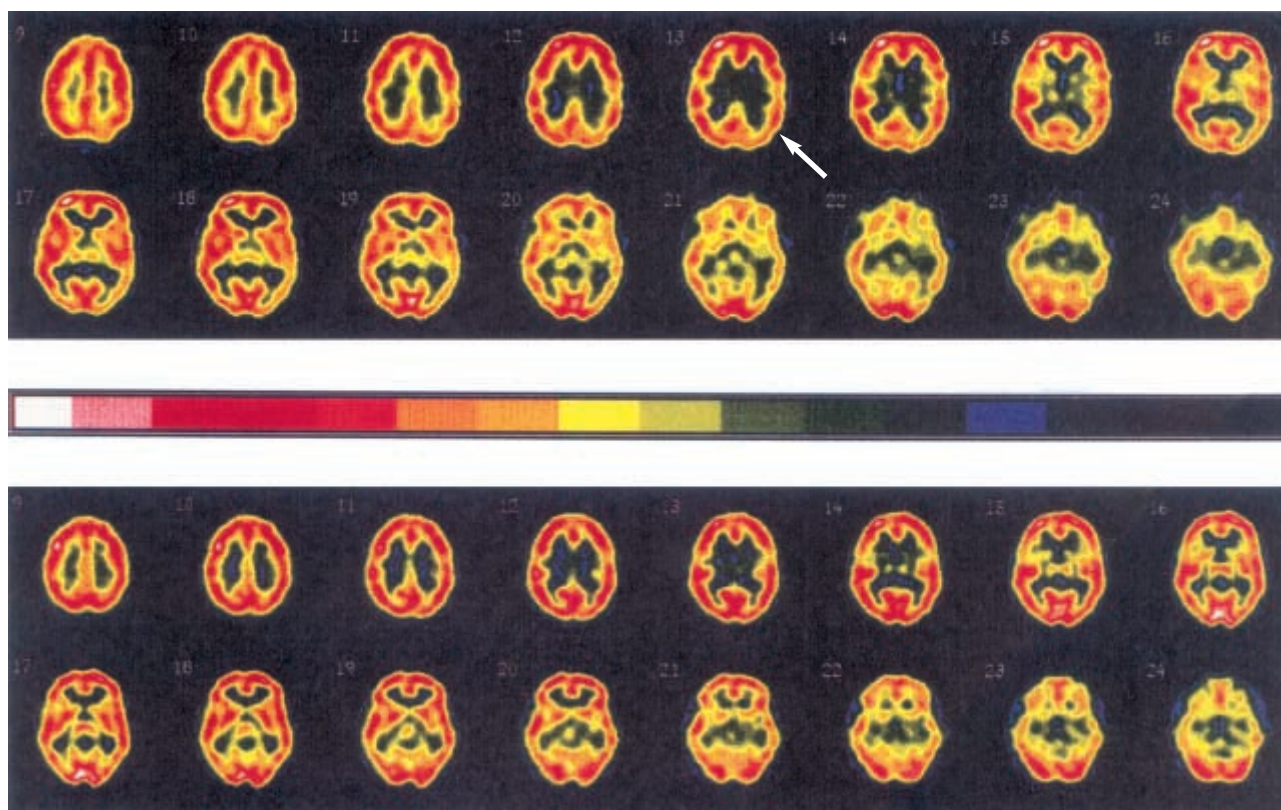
Acute phase brain SPECT showed a relative hypoperfusion in the territories of the left middle and posterior cerebral arteries (upper panel, arrow), which significantly improved as demonstrated by repeated SPECT 18 months later (lower panel).
